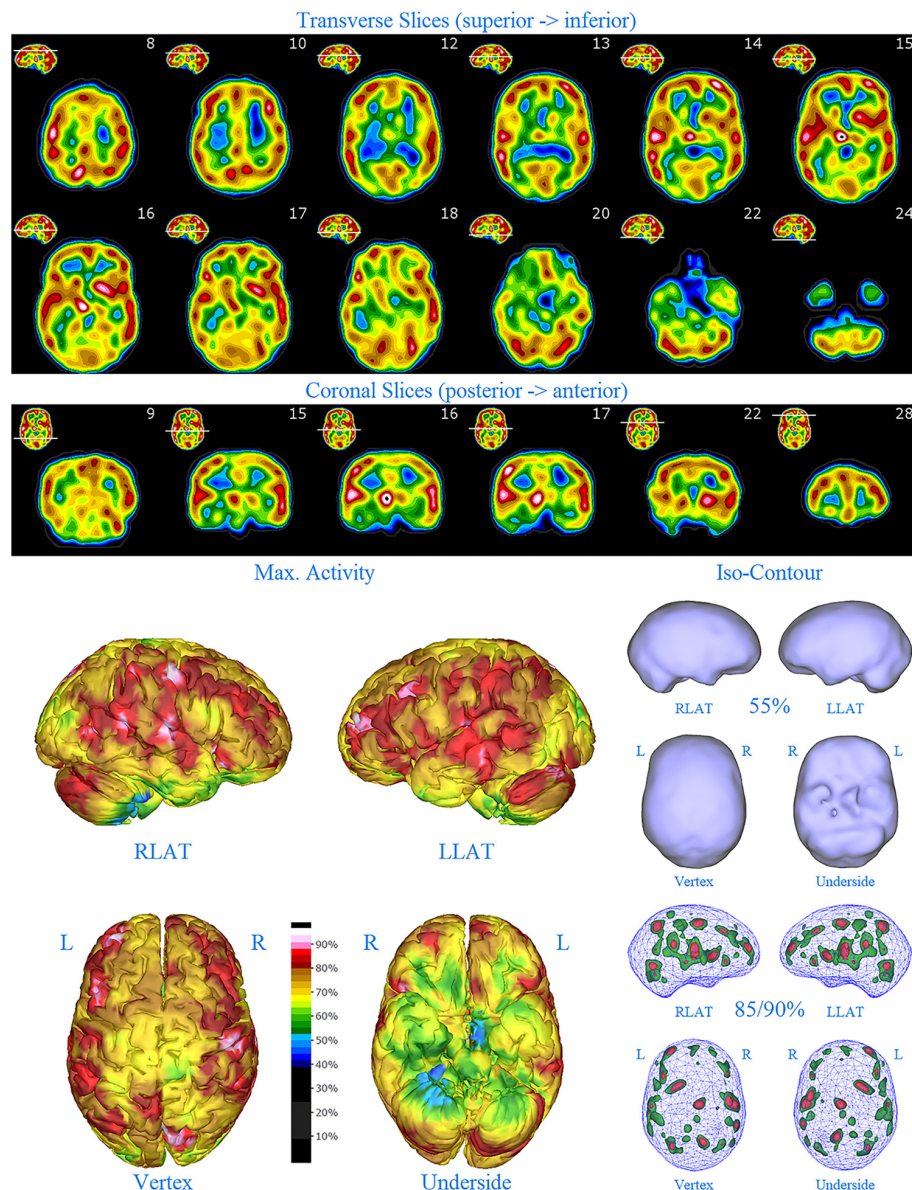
First perfusion SPECT scan of Patient E. Arrangement, color scales, and views are identical to Figure 1. Anatomical structures such as the thalamus are positioned similarly to the scan shown in Figure 2. Labeling was eliminated to avoid obscuring the scan details. Perfusion of the thalamus is intensely increased and asymmetrical. Multiple cortical areas of increased perfusion are seen throughout the cerebral cortices.
